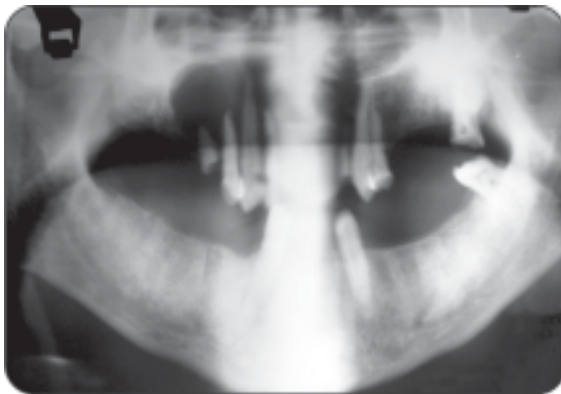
Radiograph of adenocarcinoma
